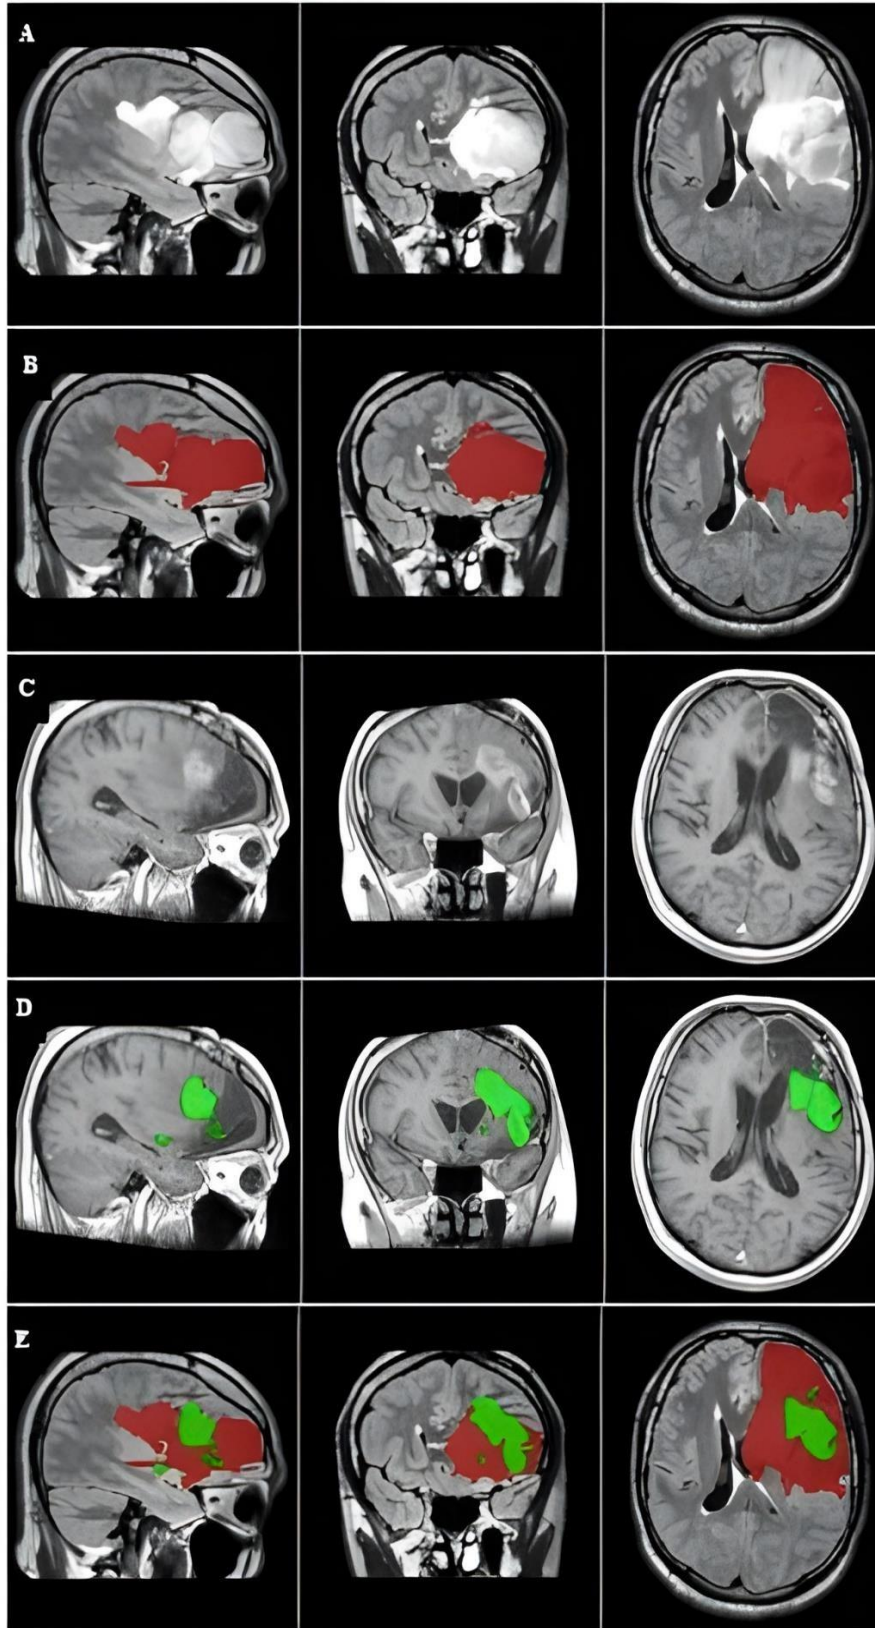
A representative case showing the primary tumor, tumor recurrence, and overlap between the two masks. The images were captured in the MNI152 1-mm space. (A) The primary tumor is visualized on preoperative FLAIR image of the left parietooccipital area. (B) Preoperative FLAIR mask covering the hyperintense region (red). (C) CE-T1 image shows progression of infiltrated tumor cells around the resected cavity. (D) The tumor recurrence mask covers the postcontrast-enhanced area where the tumor recurred (green). (E) Overlap between the primary tumor (red) and tumor recurrence (green).
